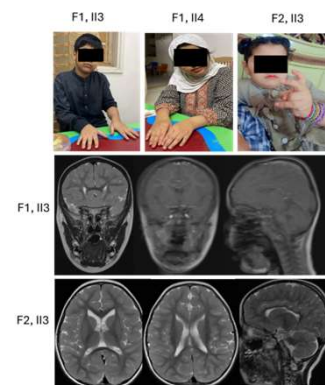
Pictures of affected individuals and brain MRI from individuals F1, II3 and F2, II3 with MRI abnormality.
